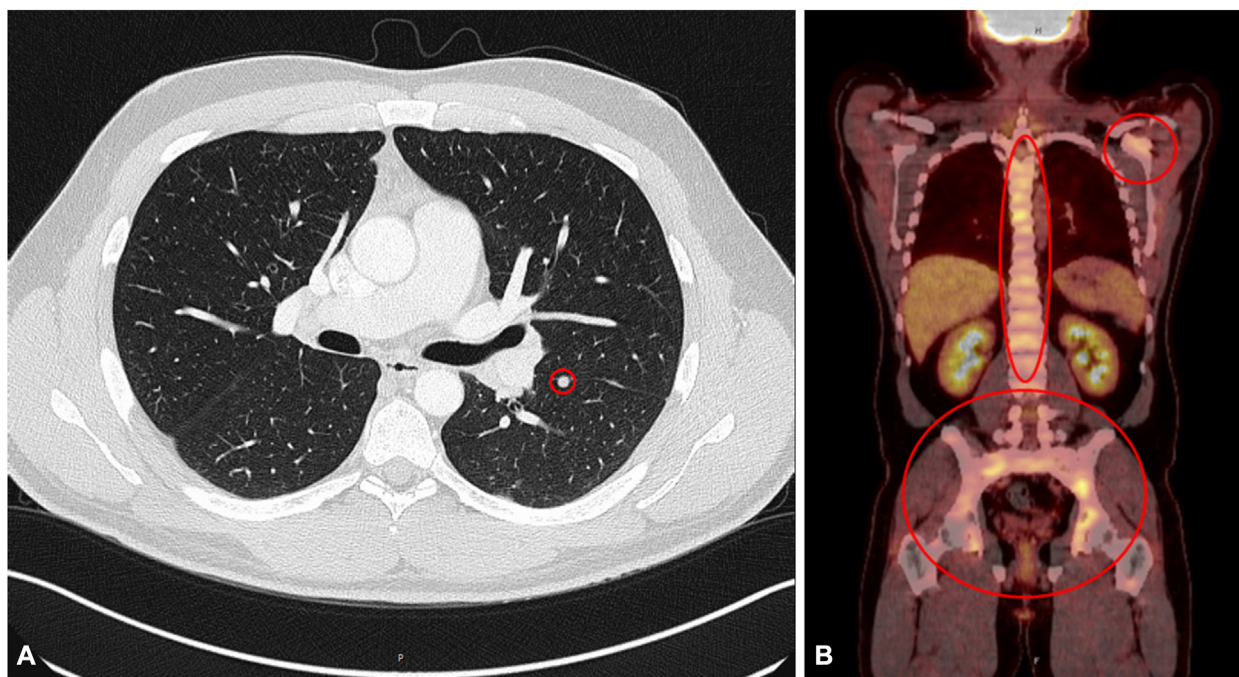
A, CT scan with pulmonary focus (*red circle*), indicating progressive disease under immunotherapy with pembrolizumab. B, PET-CT scan with multiple osseous metastases (*red circles*) indicative of progressive disease under immunotherapy with nivolumab and ipilimumab, after exhausting all treatment options the patient was treated according to the BSC concept. C, Molecular monitoring using targeted next-generation sequencing with circulating tumor DNA. Variant allele frequencies of BRAF V600E and 4 different activating NRAS mutations are given on the y-axis, the dates of blood draws are shown on the x-axis in chronological order. *BSC*, Best supportive care; *CT*, computed tomography; *PET*, positron emission tomography.
